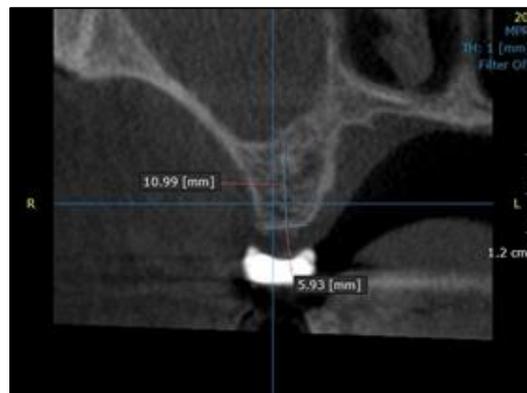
CBCT section of 16
